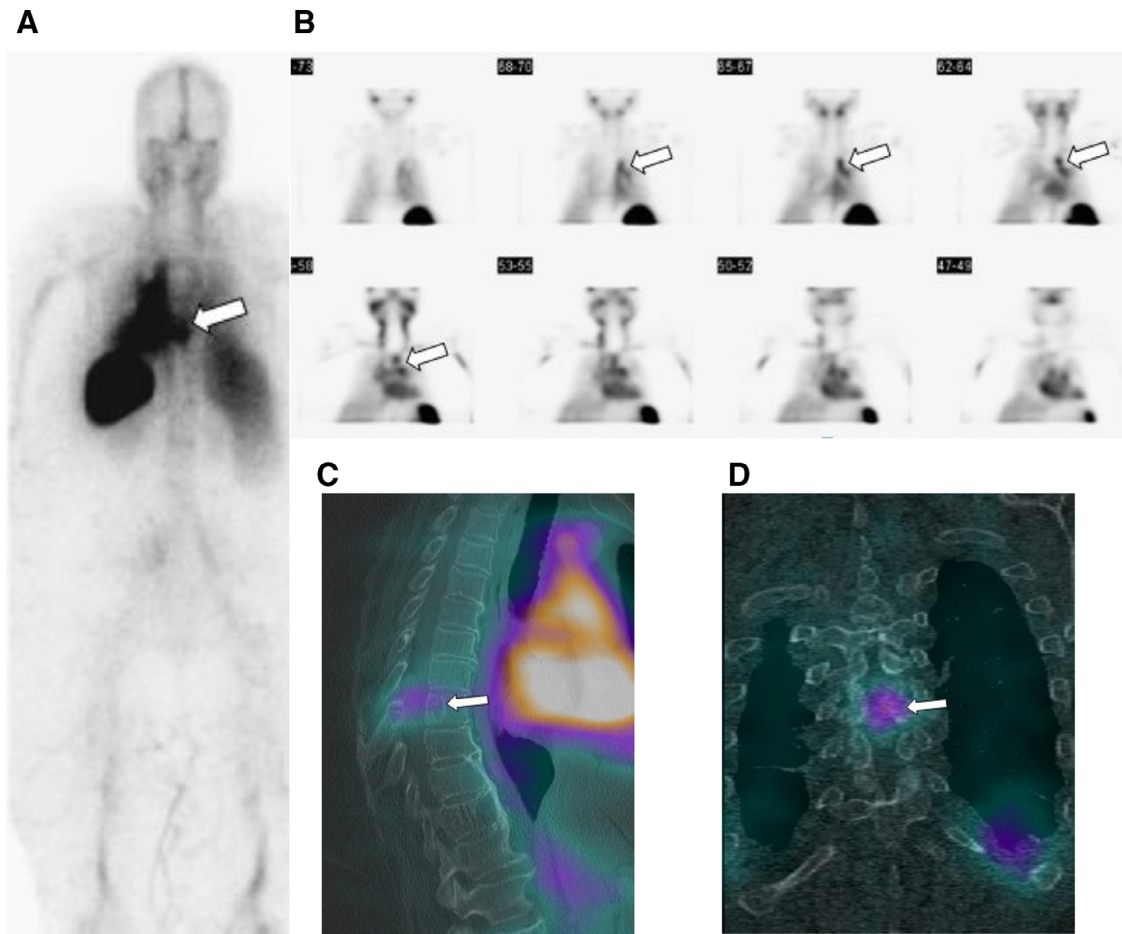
(A) Posterior planar image shows increased uptake at T7-T8 (arrow), better visualized on SPECT-CT coronal images (B, arrows). Fused SPECT-CT images (C, sagittal) show localization of the Tc-99m RBCs in the osseous lesion at T7-T8 (arrow) and its epidural soft tissue component (arrow) (D, coronal).
